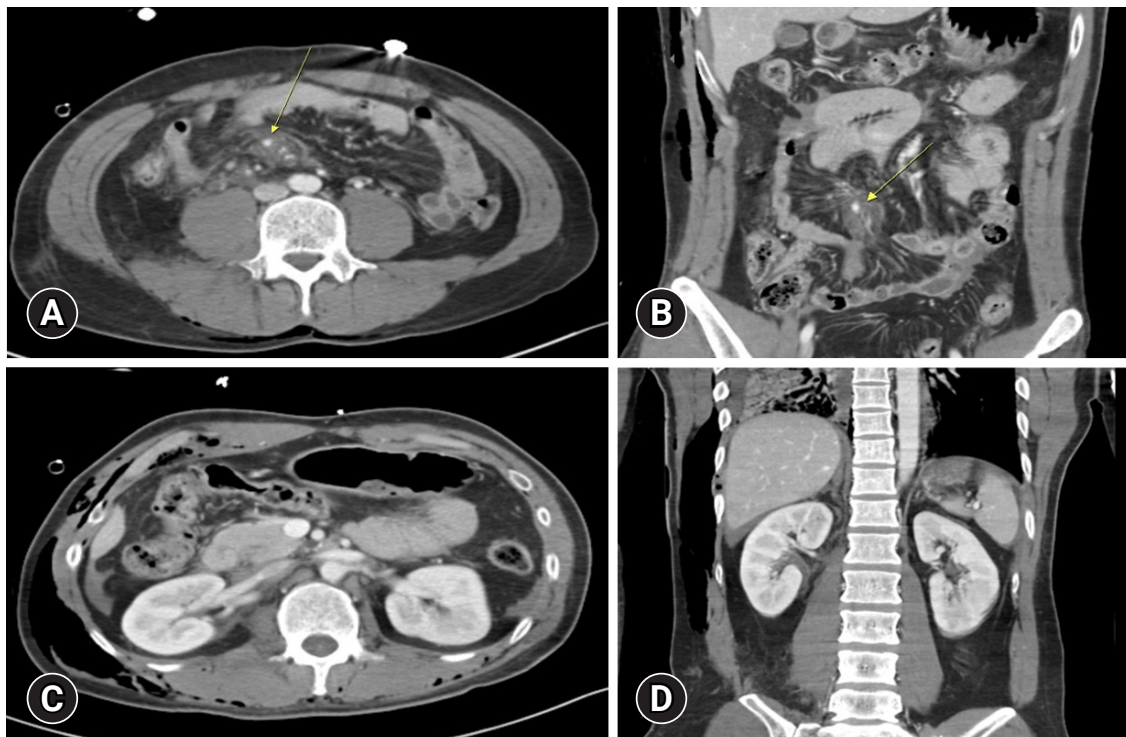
Abdominopelvic computed tomography (CT) scan images taken on the admission day with portal phase only. (A) Axial view of the initial CT scan shows the mesenteric vessel injury (arrow). (B) Coronal view of the initial CT scan shows the mesenteric vessel injury (arrow). (C) Axial view of the initial CT scan shows a minimal amount of fluid in the right perirenal space. (D) Coronal view of the initial CT scan shows a minimal amount of fluid in the right perirenal space.
